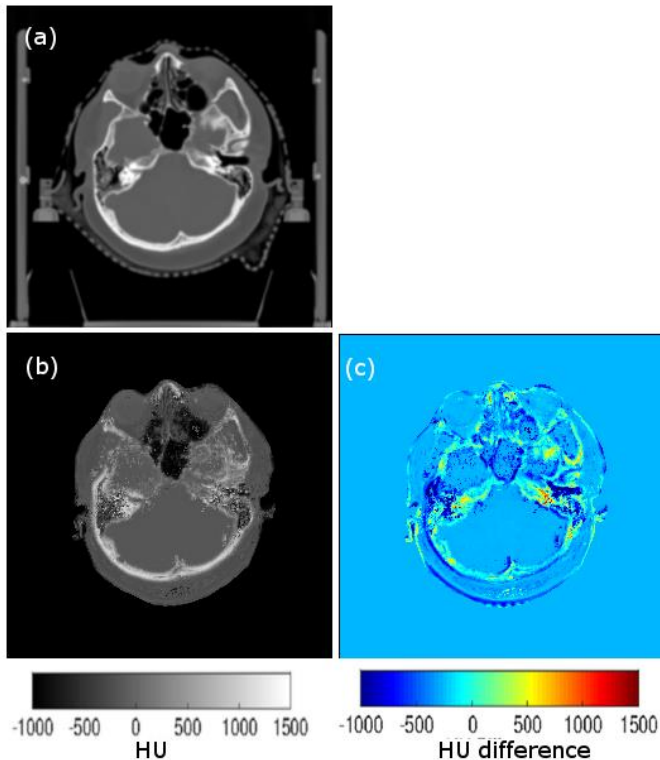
(a) Transverse slices of CT, (b) pCT (c) image difference pCT-CT
